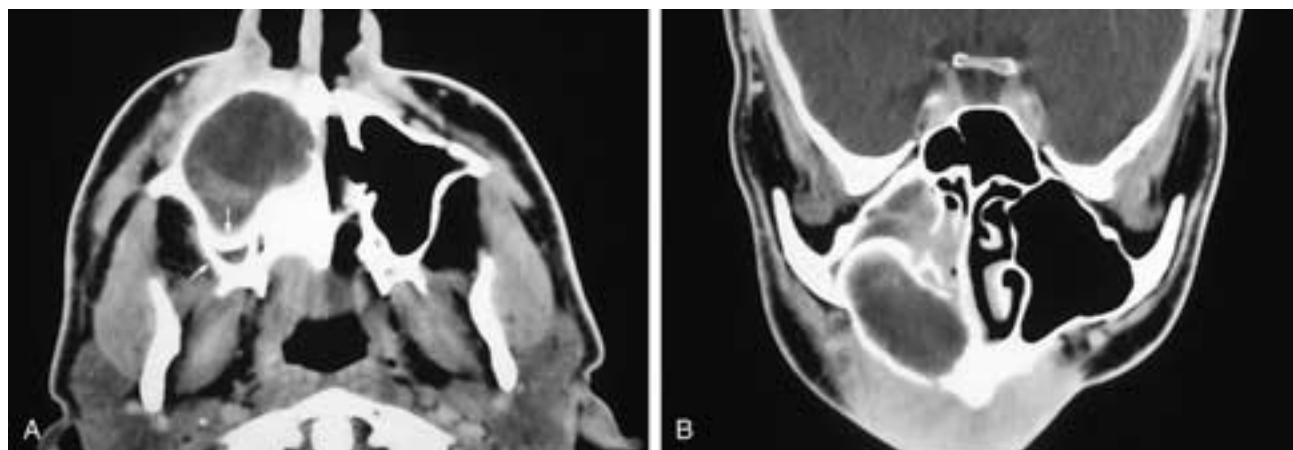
Axial (A) and coronal (B) CT scans show a water attenuation expansile mass in the lower right maxillary sinus. In A, there are two bony walls seen posteriorly (arrows). In B, they can be seen to be due to elevation of the sinus floor by a cystic mass arising below the sinus. Obstructed secretions are also present within the right maxillary sinus. This patient had a right radicular cyst and maxillary sinusitis.
